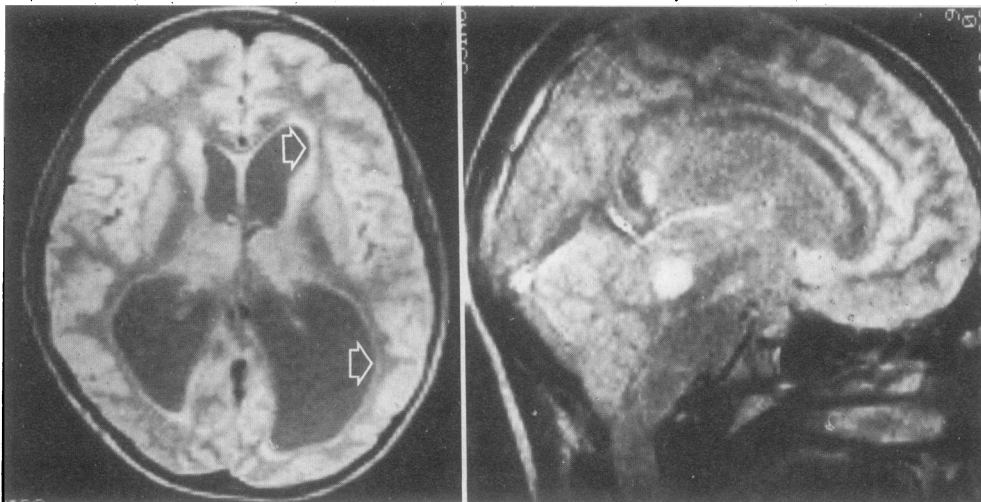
Left, A transverse spin-echo magnetic resonance image of the brain without contrast enhancement shows excellent grey- and white-matter contrast differences, substantial ventricular enlargement and a rim of periventricular edema (arrows) from cerebrospinal fluid (CSF) obstruction. Right, A sagittal image of the same patient clearly defines a high-intensity midbrain glioma, the cause of CSF obstruction.
